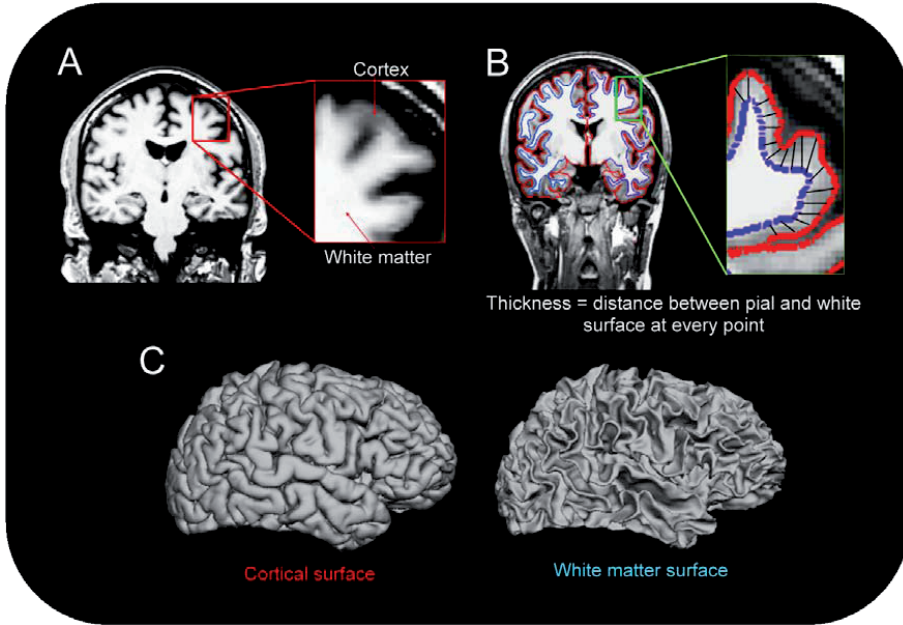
The surface reconstruction scheme employed in FreeSurfer. A) A coronal section of a T1-weighted MRI volume. The magnified part shows the contrast in signal intensity between the cortical gray and subcortical white matter. B) Automatic reconstruction of the boundaries between gray and white matter (blue) and between gray matter and cerebrospinal fluid (red). Cortical thickness is defined as the distance between the blue and the red line at every point across the cortical mantle. C) A three dimensional representation of the cortical (left) and white matter (right) surfaces.
